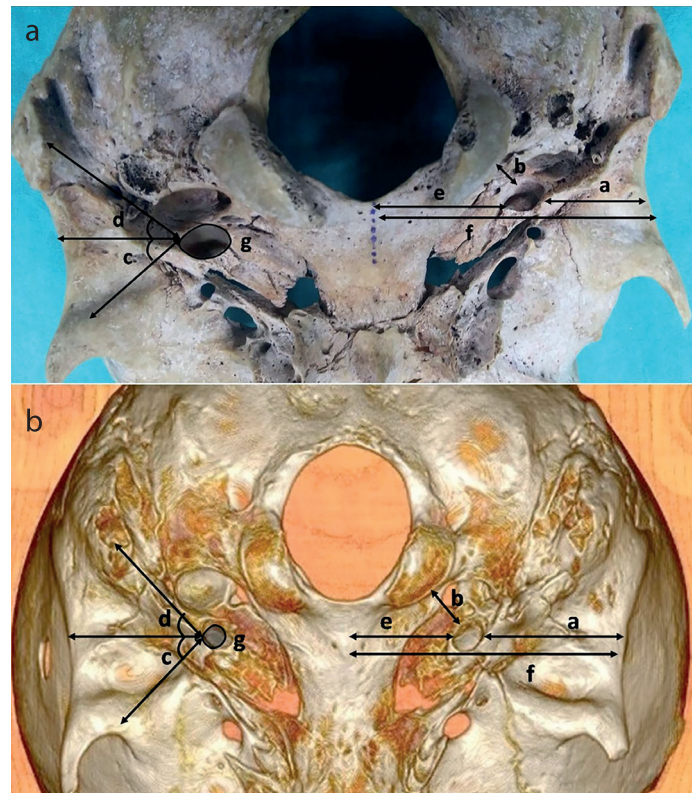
a, b. The photographs show the parameters in (a) dry skulls and (b) CT: a) the distance between CF and supramastoid crest, b) the distance between CF and occipital condyle, c) the angle between the supramastoid crest-CF-zygoma root, d) the angle between the supramastoid crest -CF-mastoid process, e) the distance between CF and midsagittal plane of the skull, f) the midline distance (at passing from middle of CF), and g) CF surface area.
